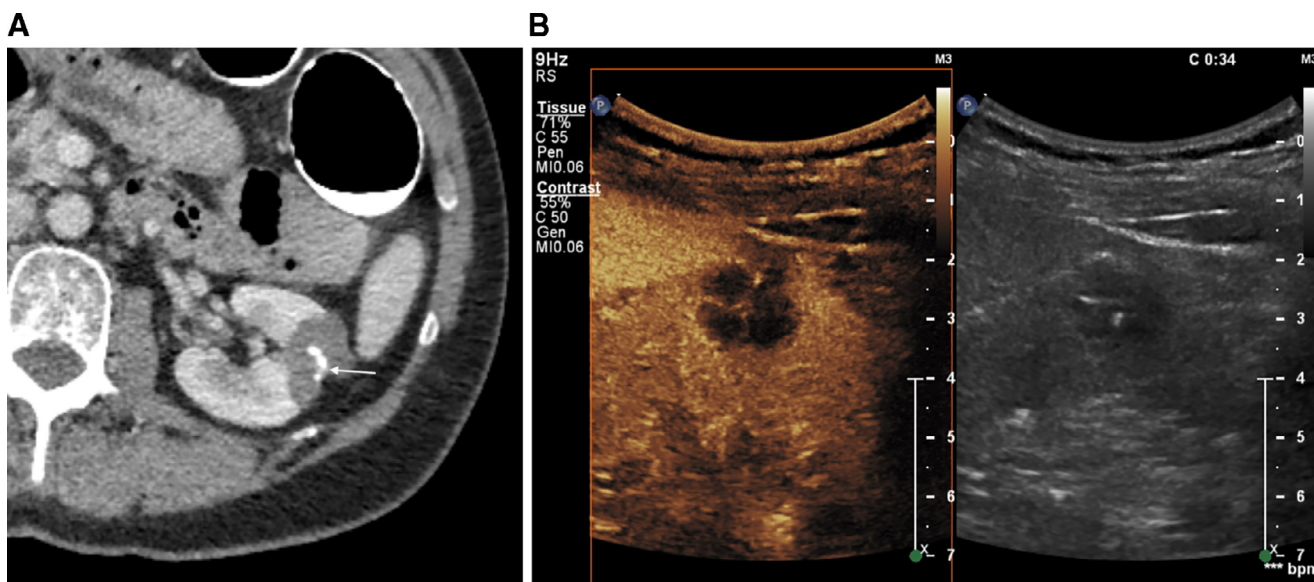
Incidental finding of a cystic lesion in a 56-year-old female. (a) Supine CT colonography performed in the portal venous phase demonstrates a complex cystic lesion in the interpolar region of the left kidney with clumped, nodular calcification. (b) On CEUS, this was shown to be a cluster of 1-1.5 cm cysts, separated by calcification. Using the original Bosniak Classification, this is IIF; based on the 2019 proposal this is II, as coarse calcification is now considered a benign finding.
